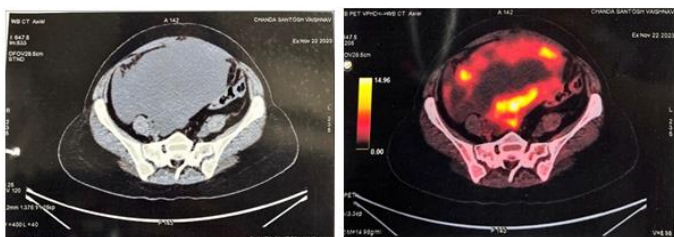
PET CT showing intrapelvic lesion of size 11.4 x 19.2 x 19.5 cm involving bilateral adnexae.
